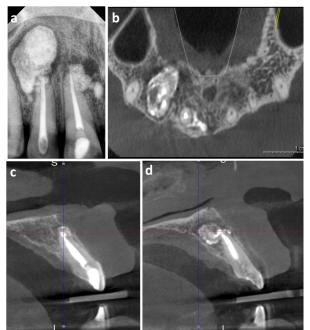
(a) IOPA IRT of teeth 11 and 12 after 3 months post-management, (b) CBCT after 3 months showing thin but defined labial and palatal cortical bone regeneration, (c) Sagittal view of tooth 11, (d) Sagittal view of tooth 12.
